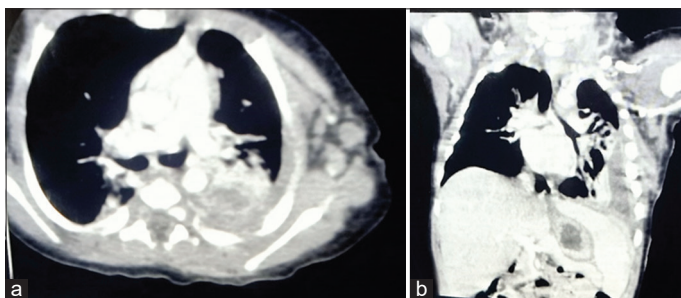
HRCT thorax showing the left lower lobe atelectasis and lung volume loss with thick and enhancing pleural membrane suggestive of empyema
